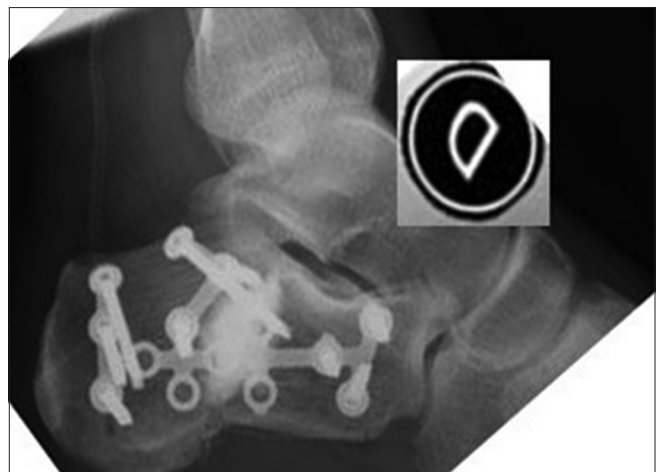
Same case. Postoperative lateral radiograph. CERAMENT™ | BONE VOID FILLER is clearly visible due to the radiocontrast agent Iohexol
